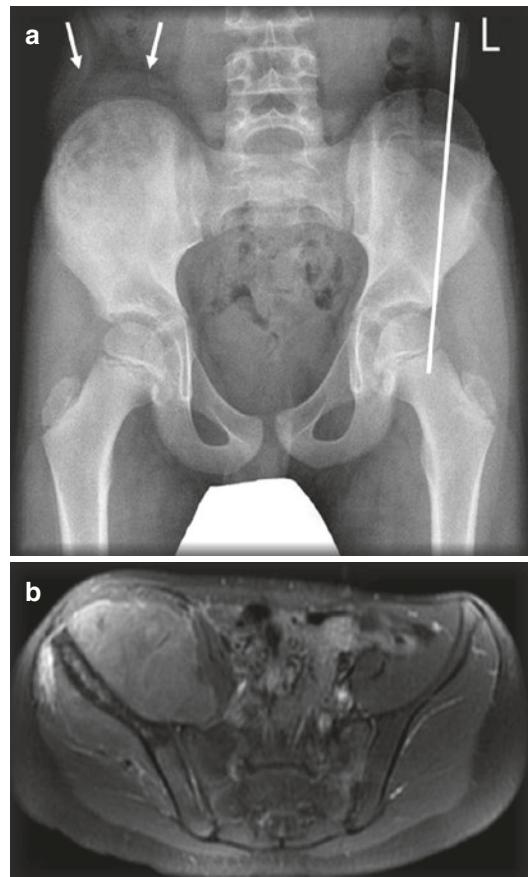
(a) AP view of the pelvis of an 11-year-old boy, showing apparent bowel contents superimposed on the lateral third of the right iliac bone, which is suspicious for a tumor. There is also a soft-tissue component along the superior aspect of the iliac crest (arrows). (b) On MRI, axial T1-weighted fat-suppressed post-contrast image shows an abnormal right iliac bone with a surrounding large soft-tissue mass, representing a Ewing sarcoma
